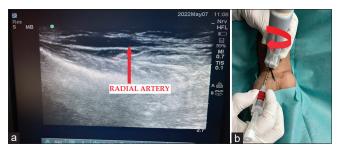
(a) Sonoanatomy of the radial artery in longitudinal oblique axis approach (elliptical in shape) with the ultrasound probe rotated at an angle of 15°–20° lateral, clockwise on the right hand. (b) Arterial cannula inserted at the midpoint of short axis of the ultrasound probe
